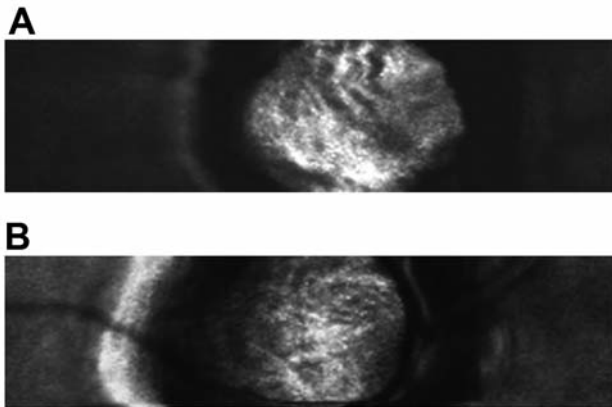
A. Original skeletonized gray scale image of vessels of lamina cribrosa as provided by SLDF (Scanning Laser Doppler Flowmetry) analysis in a glaucomatous subject showing vessels larger than  $30\ \mu\text{m}$ . B. Original skeletonized gray scale image of vessels of lamina cribrosa as provided by SLDF (Scanning Laser Doppler Flowmetry) analysis in a healthy subject showing vessels smaller than  $30\ \mu\text{m}$ .
